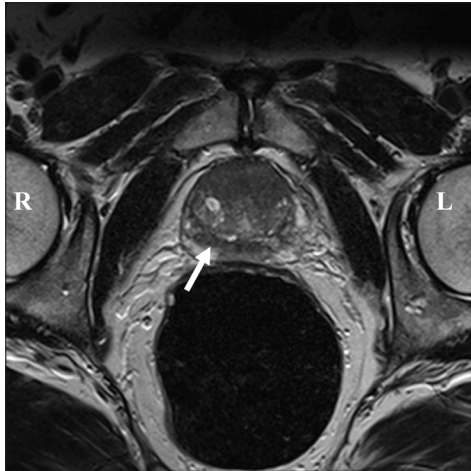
T2-weighted pelvic MRI of the prostate. Low-density areas can be seen anteriorly and in the peripheral zone on the right (arrowed). There were no reported enlarged lymph nodes
